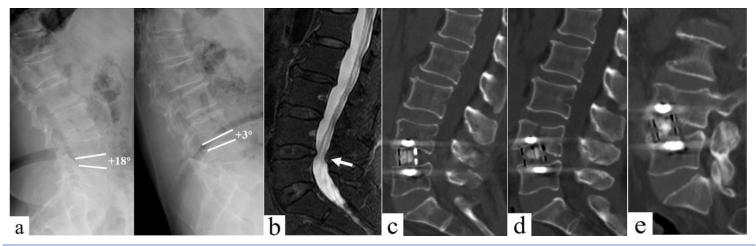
(a), preoperative dynamic X-ray radiographs revealed instability at L4-5; (b), preoperative MRI revealed spinal canal stenosis at L4-5; (c), 3D-CT taken at 1day postoperative revealed good positioning of cage within the disc space without evidence of endplate violation or cage subsidence; (d), emergency 3D-CT (7 days postoperatively) revealed coronal fracture of the L4 vertebrae, with the cage counterclockwise rotation; (e), 3D-CT taken at 12 months postoperatively revealed the vertebrae fracture healed and the successful fusion was also achieved.
